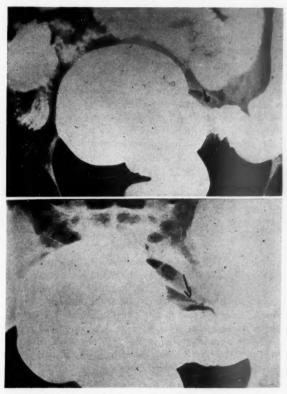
Ameboma of the sigmoid colon. Above, before treatment; below, after treatment. Note the minute serrations in the "before treatment" x-ray picture. (X-Ray Department, Tokyo Army Hospital.)
